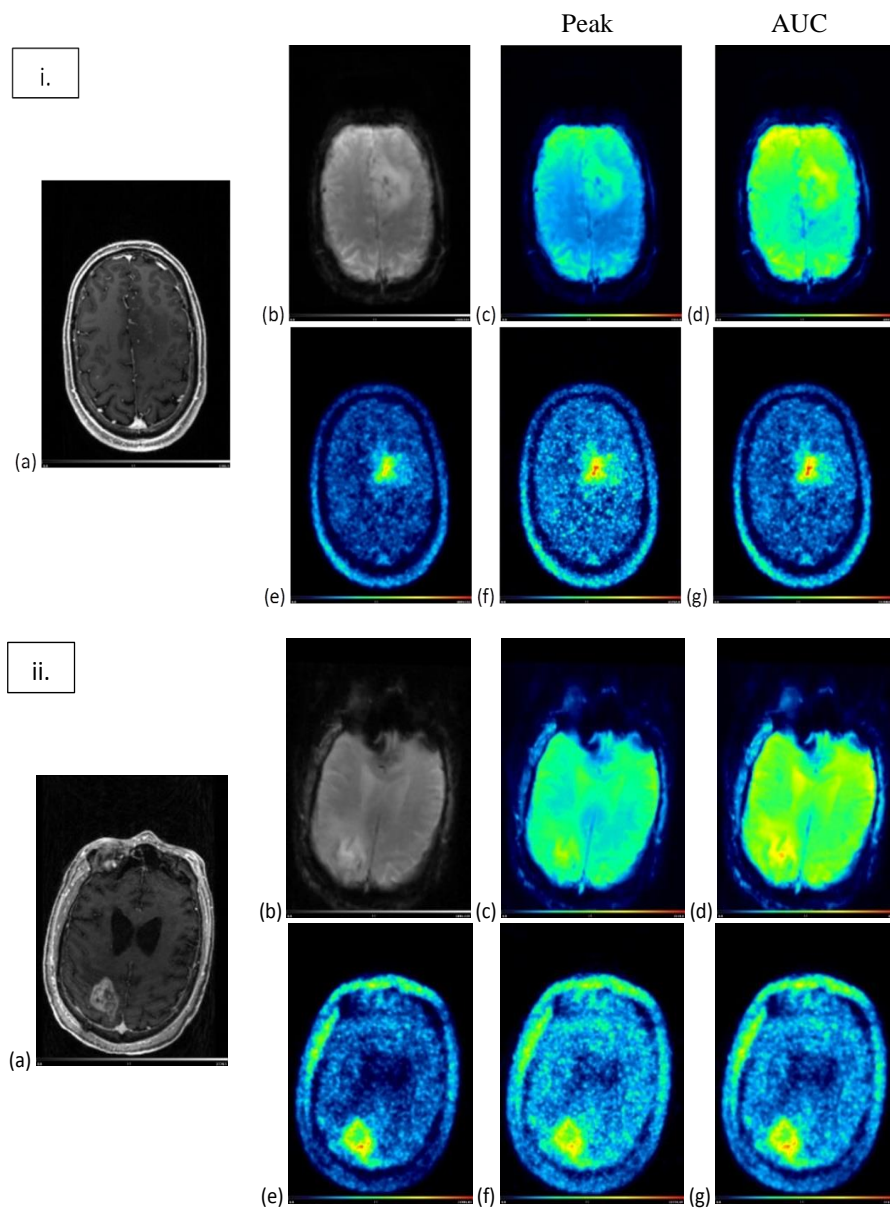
Two analysed datasets (i and ii). MRI images: MP-RAGE (post contrast) (a), EPI (b), and the corresponding extracted parametric images: peak (c) and AUC (d). FET-PET image (summed image of 20-40 min p.i.) (e) and the corresponding extracted parametric images of peak (f) and AUC (g).
